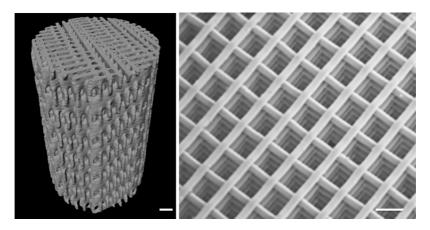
Bioactive glass scaffolds produced by the robocasting rapid prototype method. X-ray microtomography image (left) and SEM image (right) (courtesy of E. Saiz and Q. Fu. Further information in *Adv. Funct. Mater.*, 2011, 21, 10581063).
